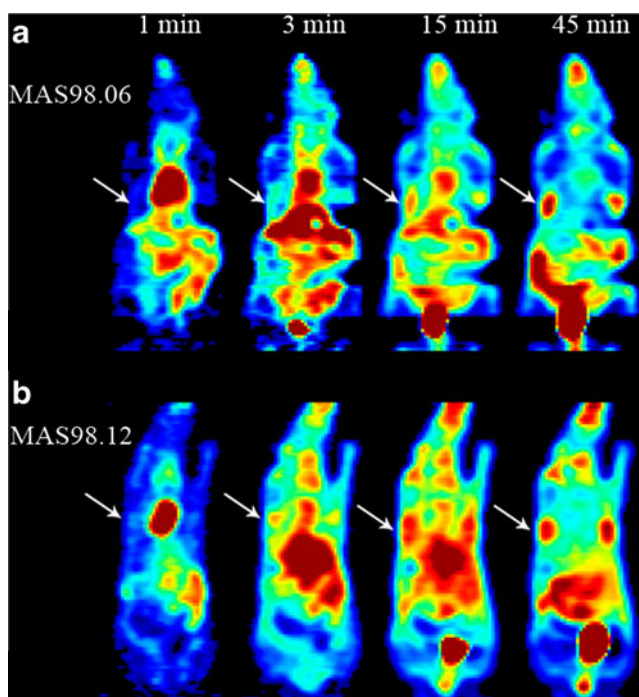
Dynamic ^{18}F -FDG PET images of the human breast cancer xenografts MAS98.06 (a) and MAS98.12 (b), at 1, 3, 15 and 45 min after bolus injection. White arrows show the locations of the tumors
